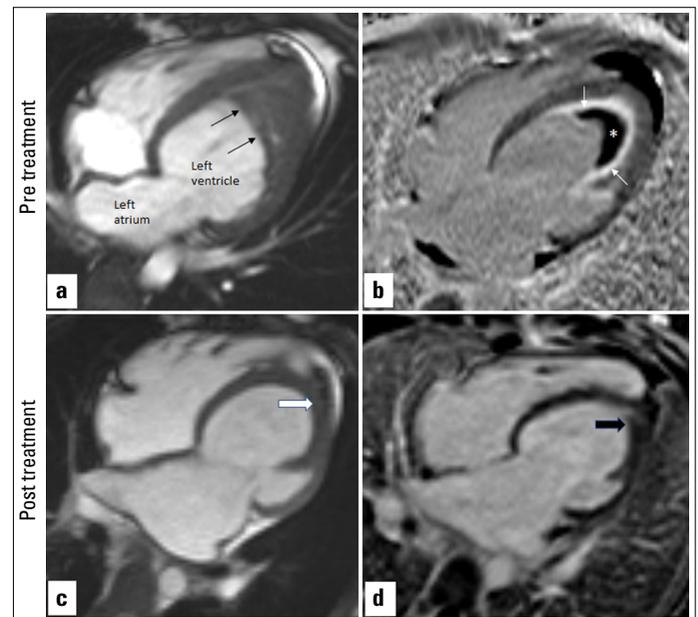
Cardiac MRI suggestive of left ventricular apical soft tissue mass with obliteration of apex. (b) Late gadolinium enhancement (LGE) images showing a non-enhancing dark mass (white asterisk) overlying the bright subendocardial enhancement (white arrows) and surrounding uniform subendocardial LGE in the apical region and papillary muscles with resultant mitral regurgitation and mild dysfunction (43%). (c) Repeat cardiac MRI was suggestive of significant reduction in the soft tissue mass at the left ventricular apex. (d) LGE image showed a complete resolution of the mass and no residual LGE suggesting complete resolution of the inflammation
